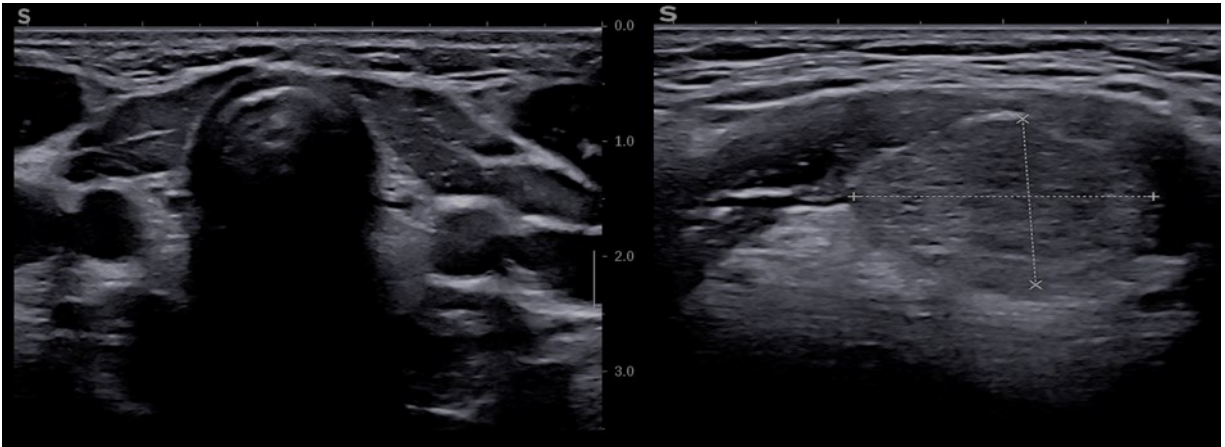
Ultrasound showing no cervical thyroid tissue (left) and sublingual scan suggesting ectopy (right)
